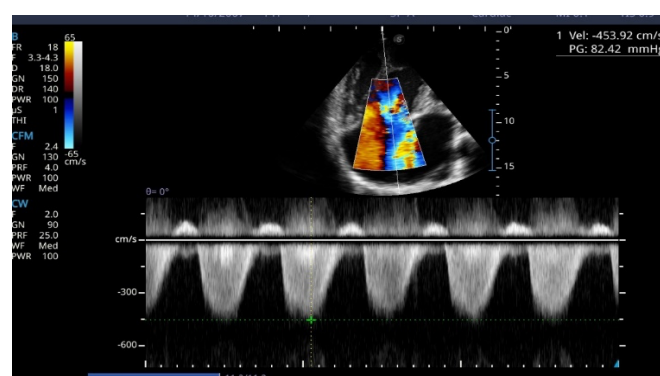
TR jet from Apical 4 Chamber View
